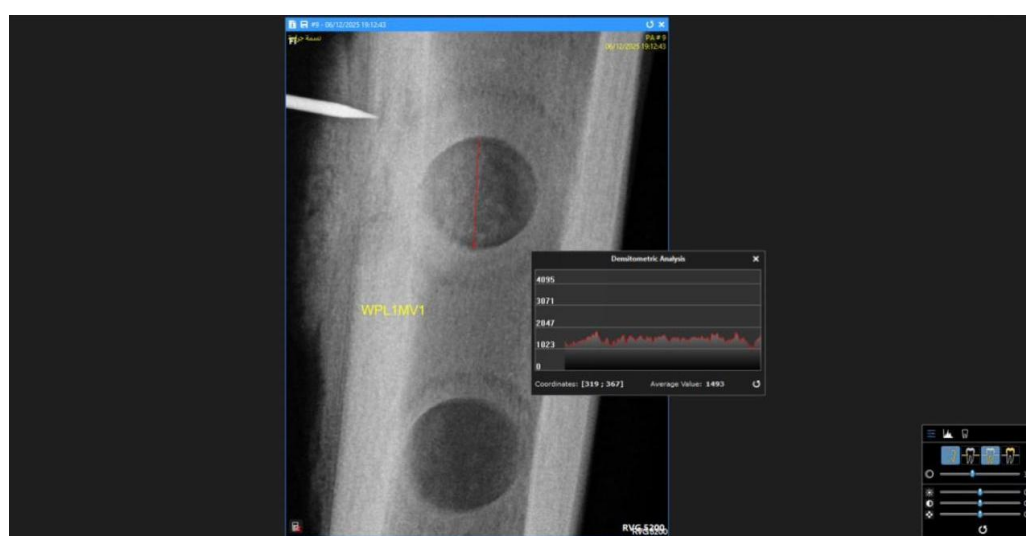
Radiographic densitometric screenshot labelled WPL1MV1, showing a selected defect-related field with an average value of approximately 1493.
